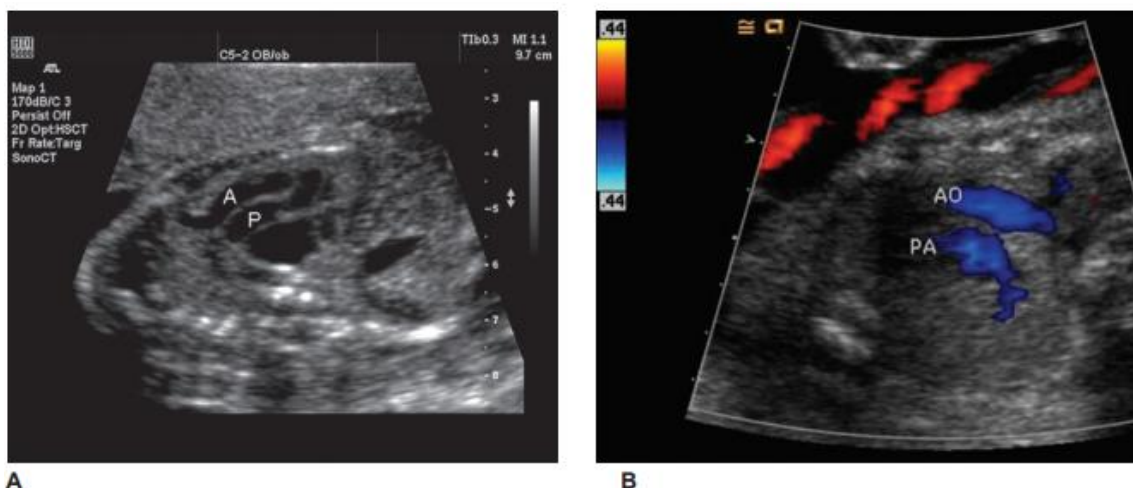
A: short axis view demonstrate the aorta (A) and pulmonary (P) arteries coming from the heart in a parallel course. B: Color Doppler imaging helps in demonstrating the vessels, confirming flow direction in the aorta (AO) and pulmonary artery (PA) [12].
